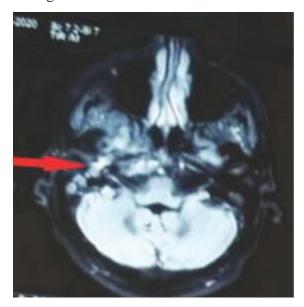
MRI Scan showing Involvement of Right Petrous Temporal Bone
